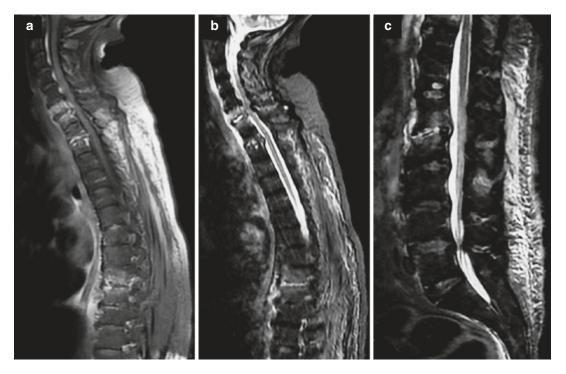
Multiple TB spondylodiscitis at cervical, thoracic, and lumbar levels. Spinal MRI sagittal views on T1-weighted image after gadolinium injection (a) and on STIR sequences (b, c) (Courtesy of Pr. Ali Akhaddar, MD, IFAANS)
